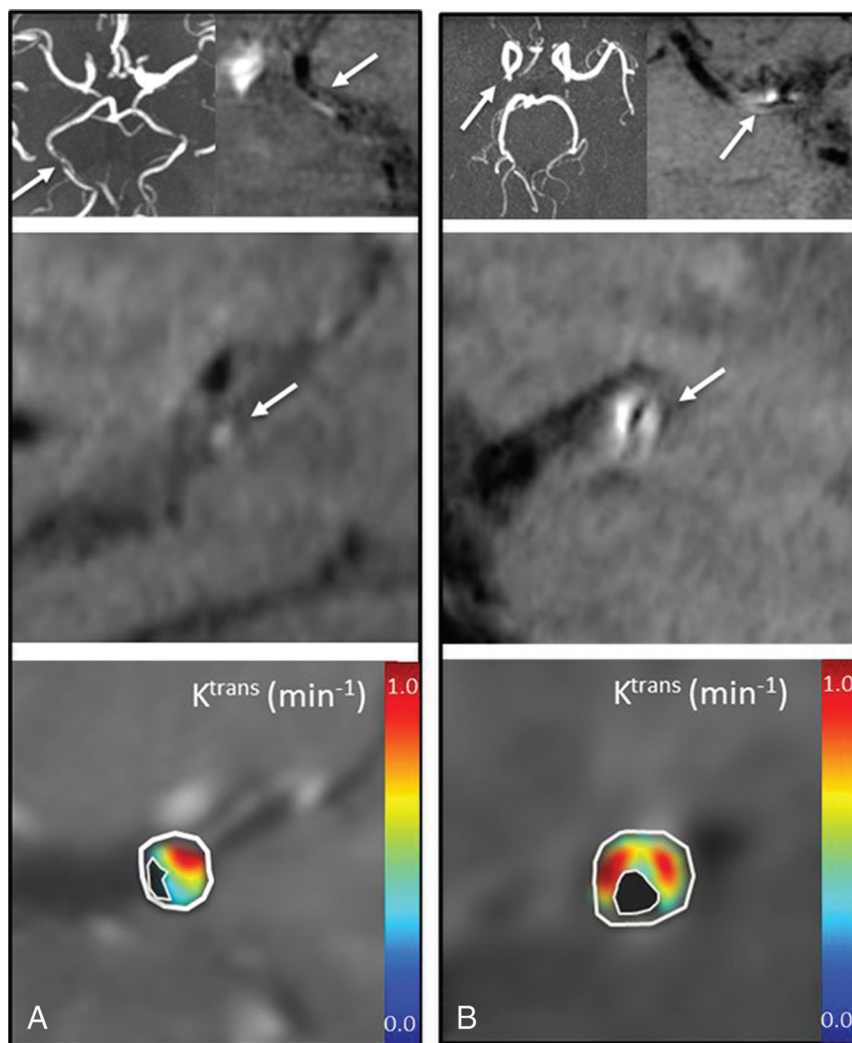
K^{trans} plaque permeability differs from relative signal enhancement in T1 SPACE imaging in 2 patients. Each panel shows axial TOF MRA (upper left), axial T1 SPACE (upper right), and sagittal T1 SPACE (middle) MR images confirming vessel patency with eccentric plaque, and K^{trans} (lower). A, A 69-year-old man with right posterior cerebral artery stenosis on TOF MRA and corresponding T1 SPACE plaque enhancement measured at 123%. K^{trans} measured at 0.39 minutes⁻¹, and V_p at 11%. B, A 54-year-old woman with right MCA stenosis and corresponding T1 SPACE plaque enhancement measured at 226%, K^{trans} measured at 0.45 minutes⁻¹, and V_p at 12%.
